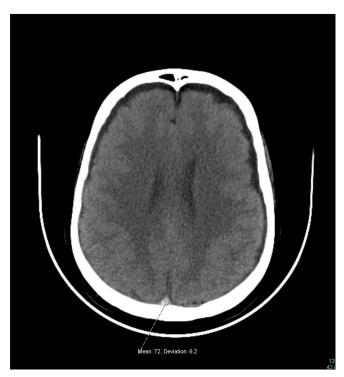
A 37-year-old woman with acute lymphoblastic leukemia who presented with headache and blurry vision. (a) Non-enhanced axial CT image of the brain shows increased attenuation of the superior sagittal sinus (HU = 72).
